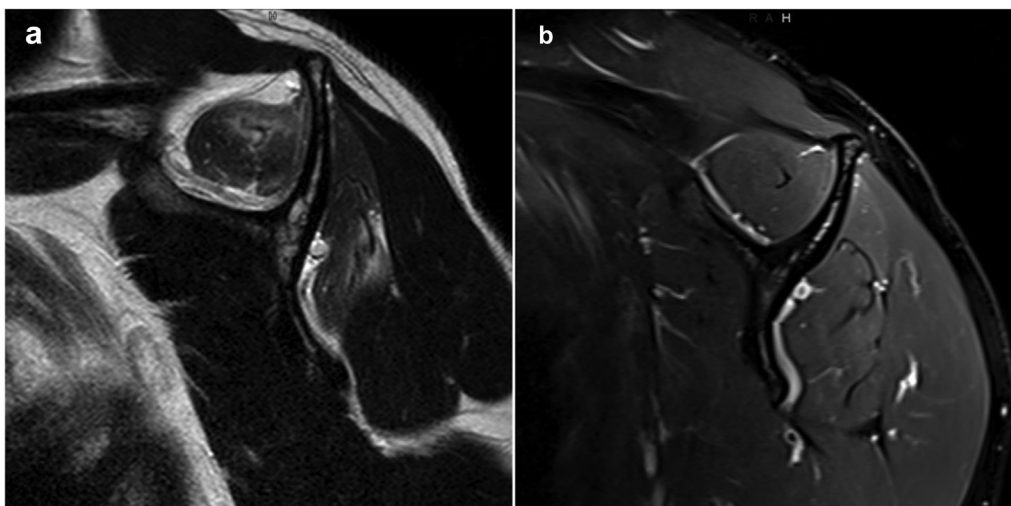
Magnetic resonance imaging (MRI), T2 turbo-spin echo sagittal (a) without fat suppression; edematous changes of the supraspinatus (SSP) and infraspinatus (ISP) muscle (b) with fat suppression. One year after trauma, the edematous changes dissipated.
